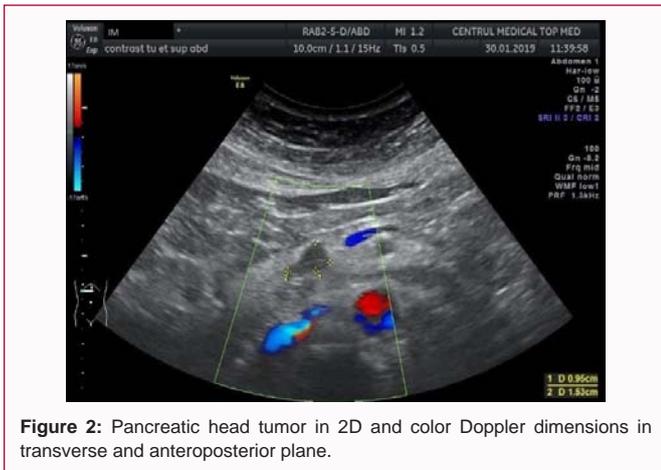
Pancreatic head tumor in 2D and color Doppler dimensions in transverse and anteroposterior plane.
